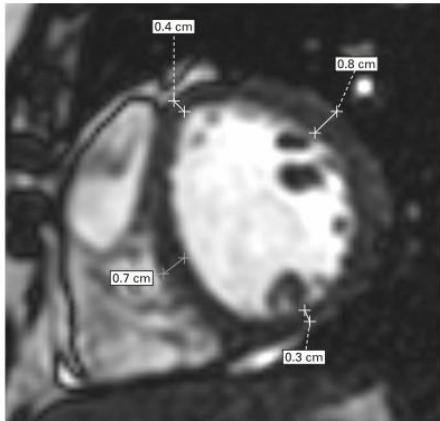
Short axis of the right and left ventricle in cine-MRI sequence showing the thickness of the left ventricle myocardium (end-diastolic frame).
